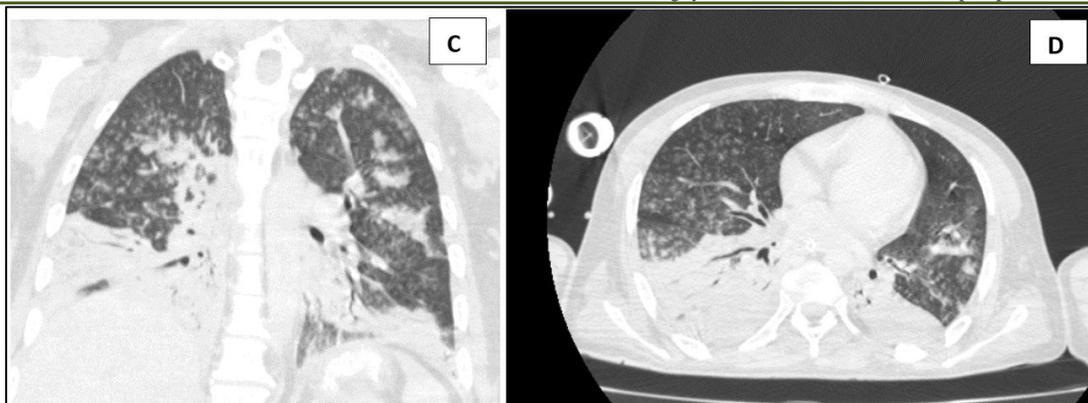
Cervico-thoracic CT scan:
